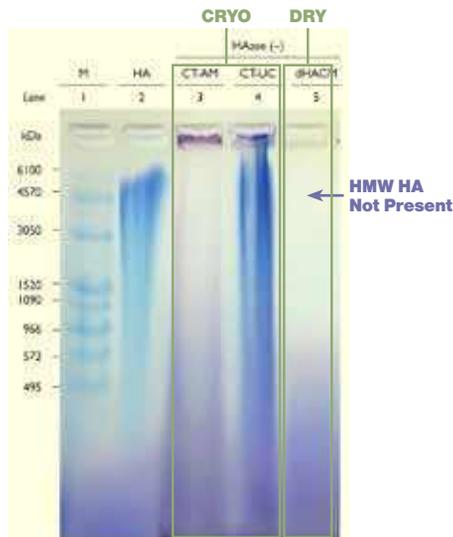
Assay showing the degree to which CAM retains HA while dehydrated amniotic membrane is depleted of it. HMW: high molecular weight. Adapted from figure 4 of Cooke M, Tan EK, Mandrycky C, He H, O’Connell J, Tseng SC. Comparison of cryopreserved amniotic membrane and umbilical cord tissue with dehydrated amniotic membrane/chorion tissue. *J Wound Care.* 2014;23(10):465-74, 476. HA: hyaluronic acid, HMW: high molecular weight, CT-AM: cryopreserved amniotic membrane, CT-UC: cryopreserved umbilical cord, dHACM: dehydrated human amnion/chorion membrane.
